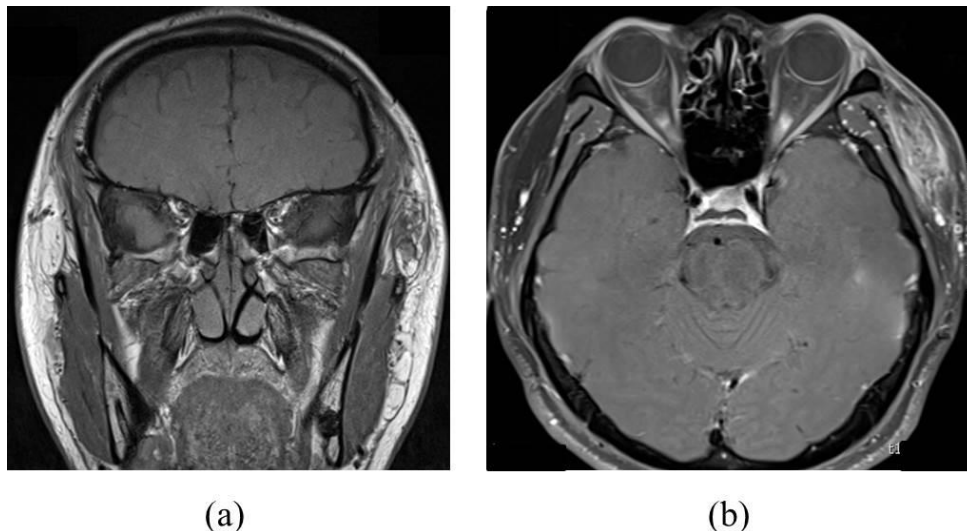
MRI images of the patient on admission (a) coronal view; (b) axial view.
